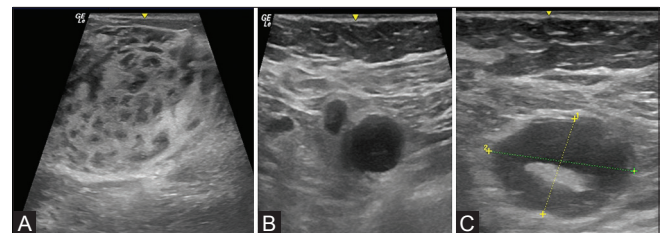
(A-C) (A) Ultrasound showing a large hyperechoic lesion in the right breast with multiple round to oval hypoechoic nodules. (B) Round, hypoechoic, enlarged axillary nodes with loss of normal fatty hilum, and (C) a few nodes with slit-like configuration of hilum
